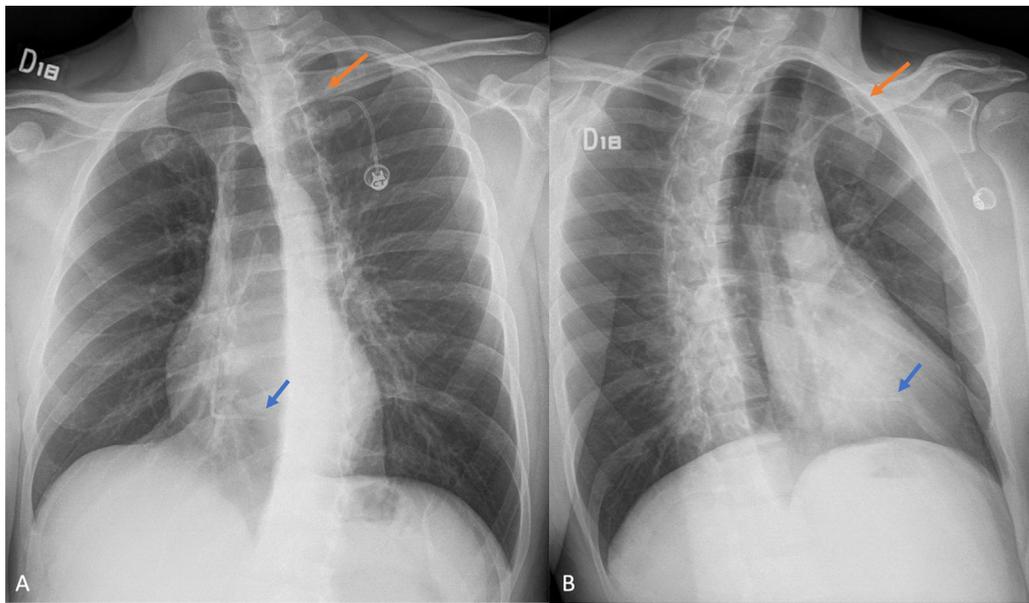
Chest X-rays right (A) and left (B) oblique projections confirming the rupture of the catheter (orange arrows) with its distal segment lodged in the right ventricle (blue arrows).
